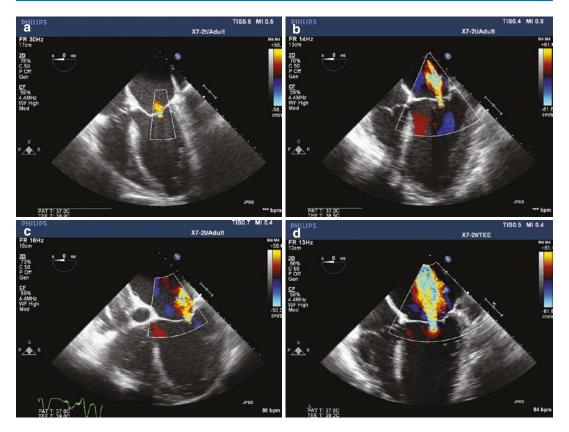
Midesophageal four-chamber views with color flow Doppler demonstrating increasing MR severity. (a) Trace (1+). (b) Mild (2+). (c) Moderate (3+). (d) Severe (4+)
